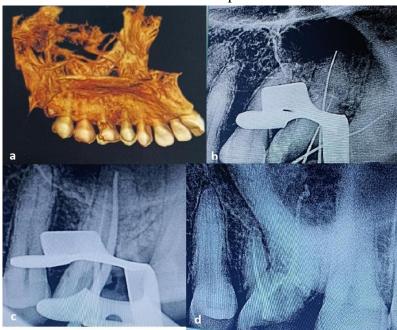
a) CBCT analysis of pathology in distobuccal root and mesiobuccal root of 26.
